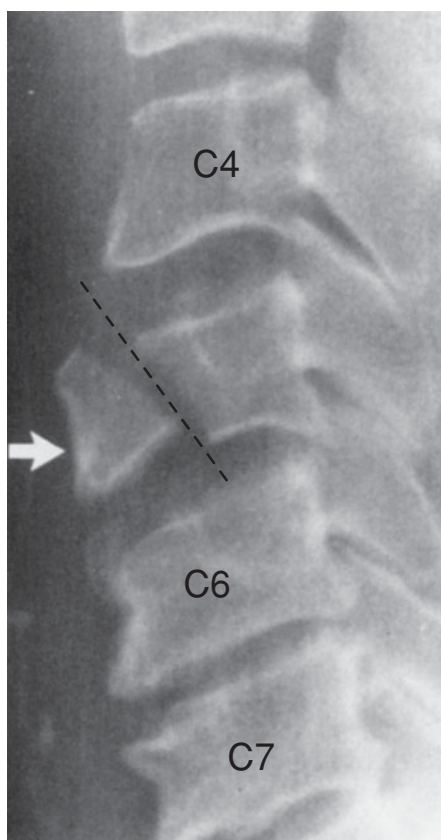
Lateral radiograph of a traumatic spondylolisthesis.
